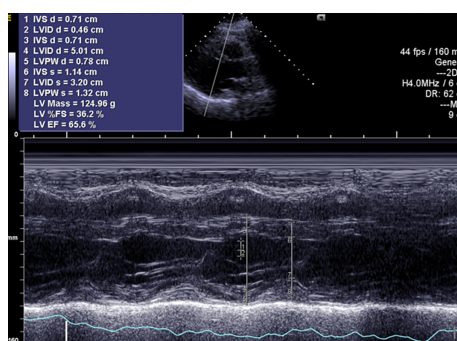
Echocardiography at the 4-mo follow-up. Left ventricular size and left ventricular systolic function returned to normal. The ejection fraction was 65.60%.
